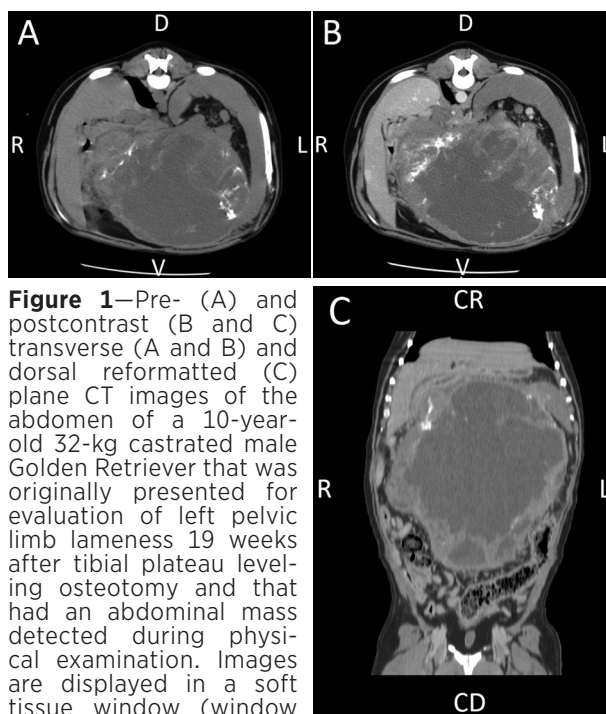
Pre- (A) and postcontrast (B and C) transverse (A and B) and dorsal reformatted (C) plane CT images of the abdomen of a 10-year-old 32-kg castrated male Golden Retriever that was originally presented for evaluation of left pelvic limb lameness 19 weeks after tibial plateau leveling osteotomy and that had an abdominal mass detected during physical examination. Images are displayed in a soft tissue window (window width, 350 HU; window level, 40 HU) with 0.62-mm slice thickness. A and B—Images were obtained at the level of T12. C—The image was obtained at the level of the pubic symphysis. CD = Caudal. CR = Cranial. D = Dorsal. L = Left. R = Right. V = Ventral.
